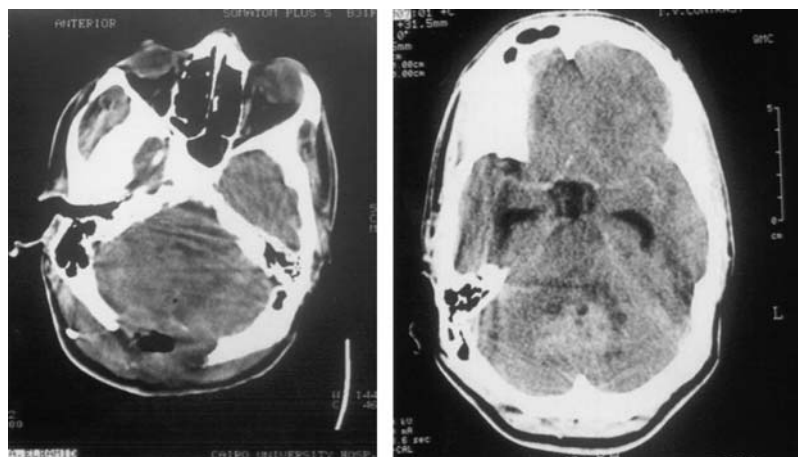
Preoperative and postoperative CT scan of posterior fossa medulloblastoma.
